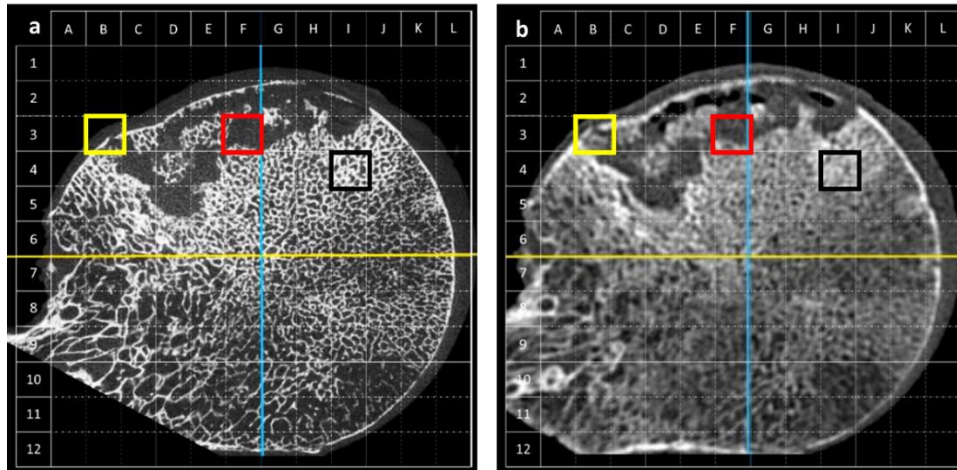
Corresponding (a) μ CT and (b) MDCT coronal reformats of an osteonecrotic femoral head. A cortical bone microfracture is visible in both B3 grid boxes highlighted in yellow. Bone resorption is visible in both F3 highlighted in red. Bone sclerosis is visible in both I4 (highlighted in black).
